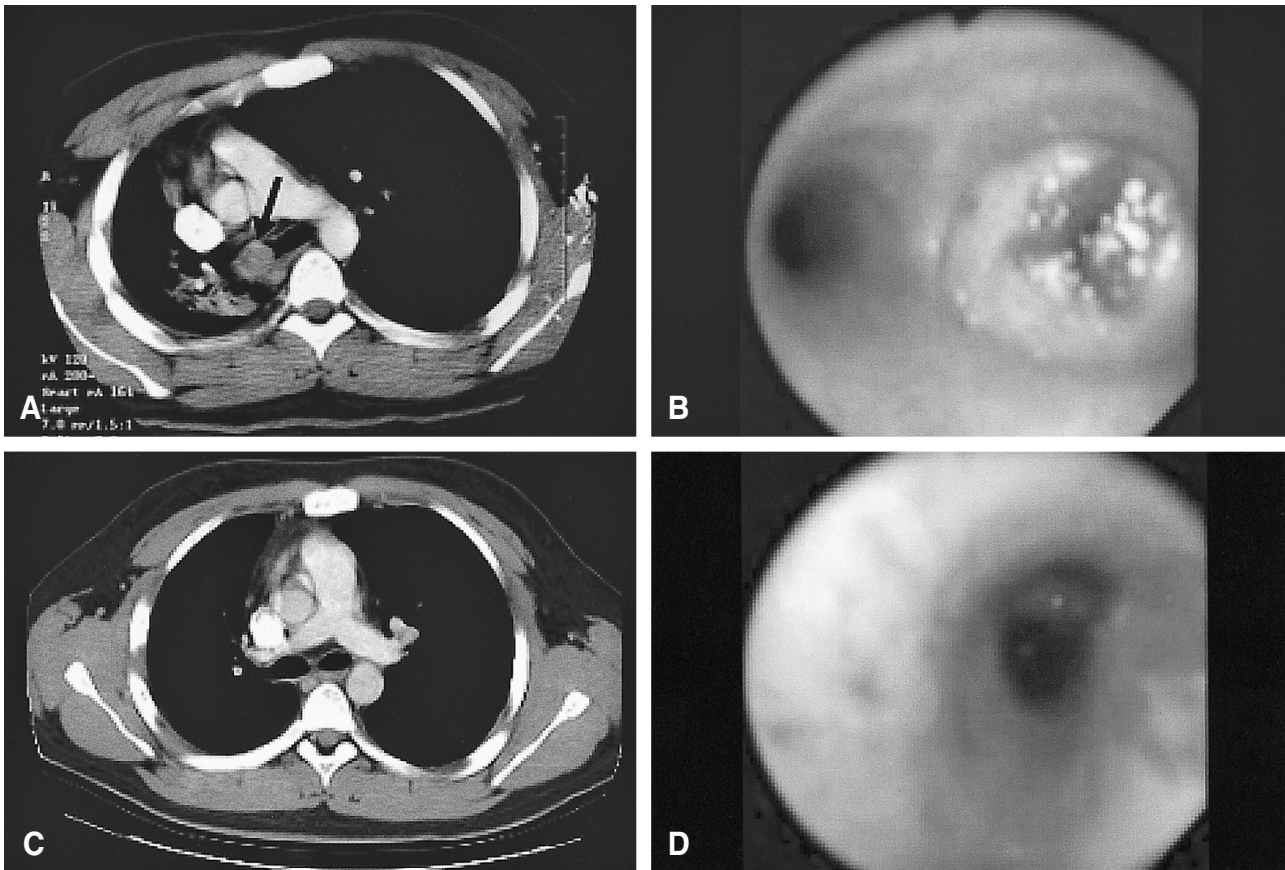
Eighteen-year-old male patient with an endobronchial leiomyoma. (A) Chest CT revealed an obstructive mass (arrow) in the right main bronchus with mediastinal shifting to the right. (B) Bronchoscopy revealed a completely obstructive mass in the right main bronchus. (C) Three months after endoscopic surgery, chest CT revealed there was no endobronchial lesion or recurrence. (D) Just after endoscopic surgery, the right main bronchus was reopened.
